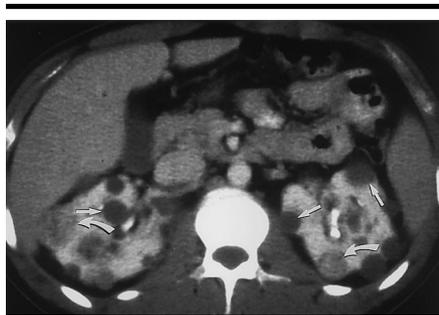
VHL disease in a 22-year-old man in whom multiple cysts (straight arrows) and solid renal cancers (curved arrows) were incidentally discovered on transverse CT image obtained because of abdominal pain. The appearance of cysts and solid masses is typical of lesions found in VHL disease.
